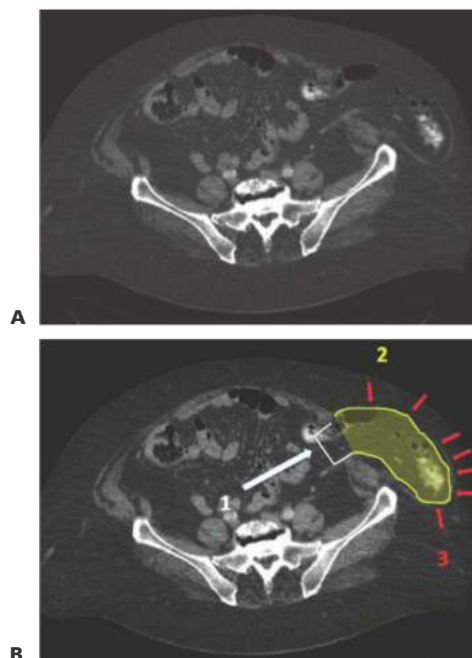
• A. CT of a patient with a left-sided spigelian hernia. The hernia defect is located lateral to the rectus sheath. The hernia sac contains a loop of the sigmoid colon. The external oblique muscle covers the hernia sac. B. 1 (white) The hernia defect in the abdominal wall muscles just lateral to the rectus sheath. 2 (yellow) The hernia sac with a sigmoid colon loop 3 (red) the intact external oblique muscle covers the hernia sac.
